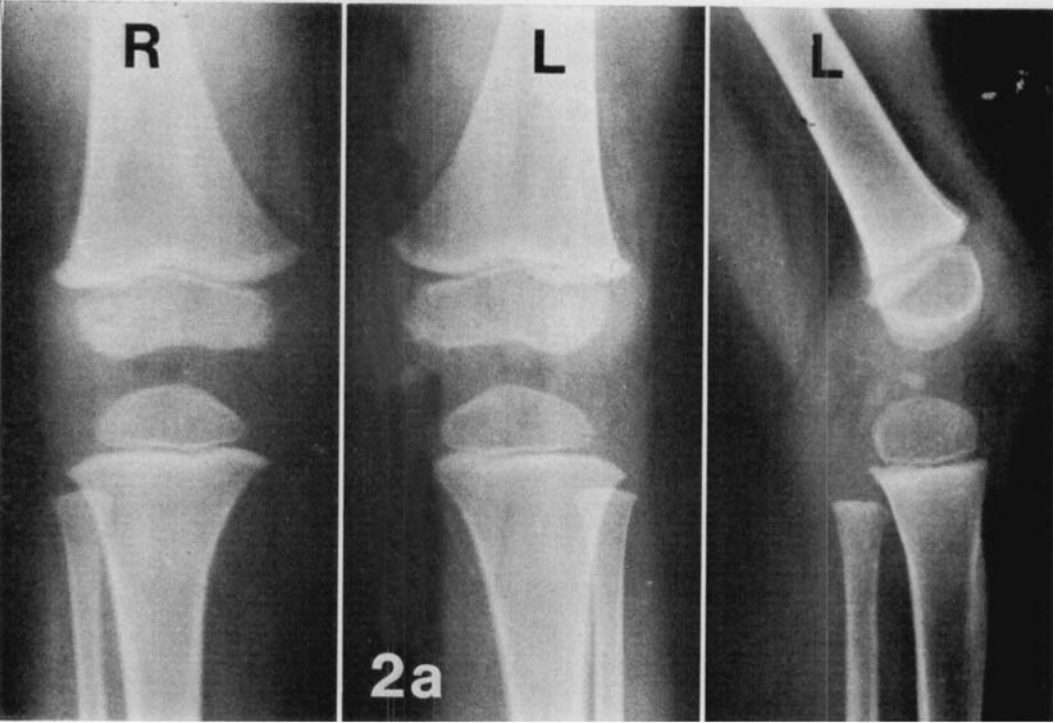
Case 1. a) X-rays of the knee joints of a girl 3 years of age. Separated ossification centres are seen at the left medial femoral epiphysis. An exostosis is present in the tibial metaphysis. b) The osteochondroma was fused to the epiphysis at 4 years. c) The knee at 5 years, 1 year after resection of the femoral condyle. A new irregular ossification centre is seen at the medial tibial epiphysis. The X-rays of the left knee at 8 (d), at 13 (e) and at 23 years (f) show a spontaneous development towards an almost normal joint.
